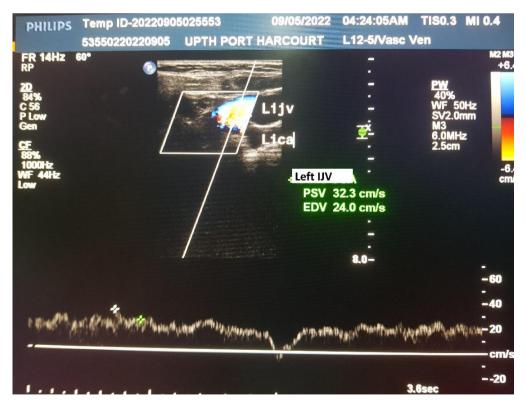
Longitudinal spectral wave sonogram showing high-velocity arterialized waveform in the left IJV
